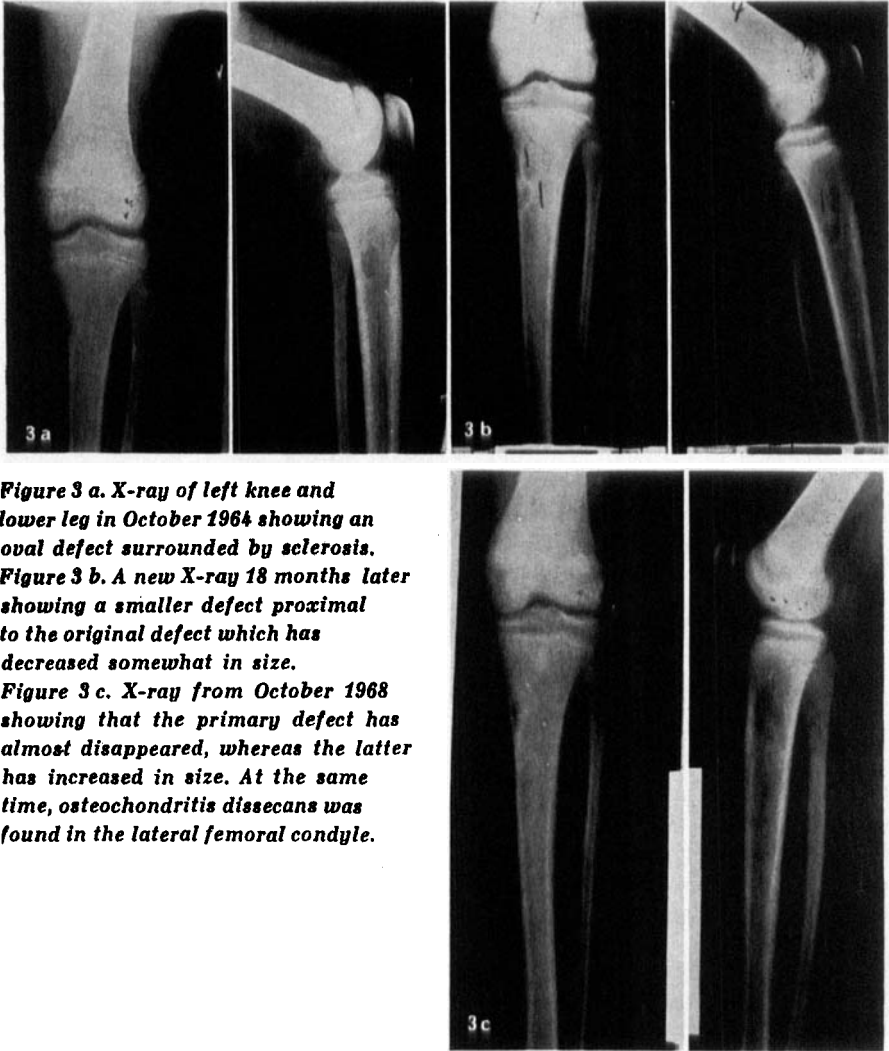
a. X-ray of left knee and lower leg in October 1964 showing an oval defect surrounded by sclerosis.
